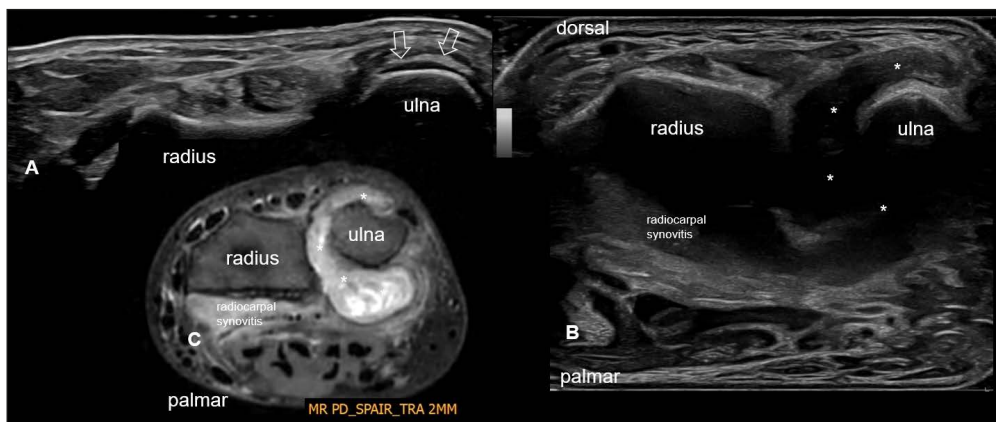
Distal radioulnar joint in B-mode (A, B) and MRI image (C) showing ultrasound evidence of a “double contour” (void arrows) at the level of the ulna and synovitis in the recessus sacciformis (white asterisks).
